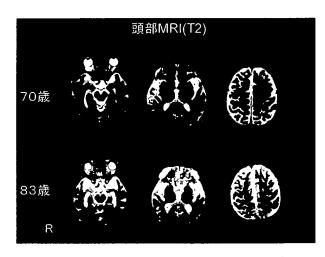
進行性の前頭・側頭葉萎縮。MRI T2 強調 画像
